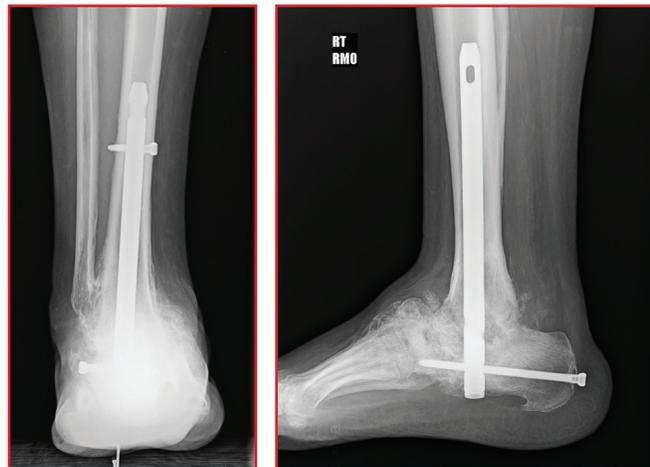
Weight-bearing AP and lateral x-rays of the ankle 6 month status post surgery demonstrating a stable well aligned foot
